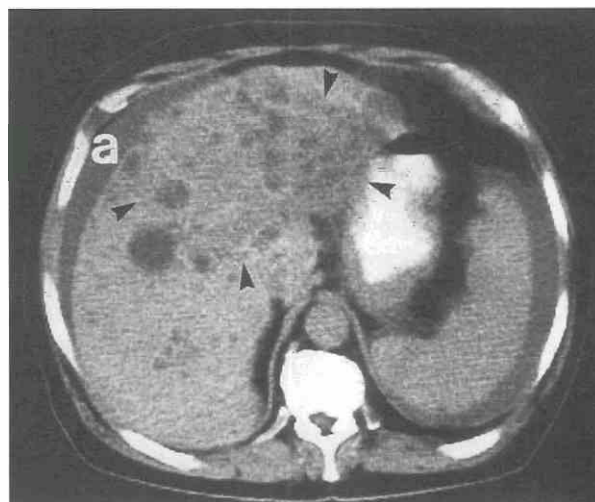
Autosomal dominant polycystic kidney disease complicated by cholangiocarcinoma in a 69-year-old man complaining of abdominal pain and weight loss. Liver function values were notably abnormal. CT scan shows several cysts in the right lobe of the liver. A poorly defined, low-density mass (arrowheads) involves the left lobe and part of the anterior segment of the right lobe. Ascites (a) is present. The neoplasm was not resectable, and the patient died from metastatic disease. (From Levine E, Cook LT, Grantham JJ: Liver cysts in autosomal-dominant polycystic kidney disease: Clinical and computed tomographic study. *AJR Am J Roentgenol* 145:229-233, 1985.)
